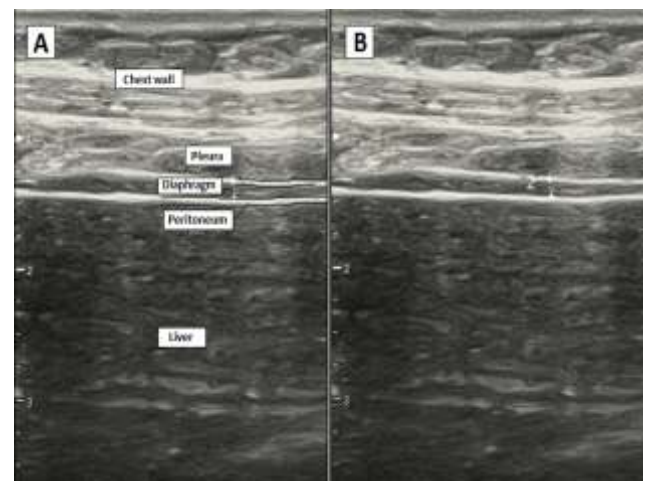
An image of the right hemidiaphragm obtained by ultrasonography in zone of apposition with the diaphragm labeled between the pleura and peritoneum as seen from a hepatic window [A] The same picture of diaphragm can be identified without labels, the distance between the cross marks represents diaphragmatic thickness [B].
